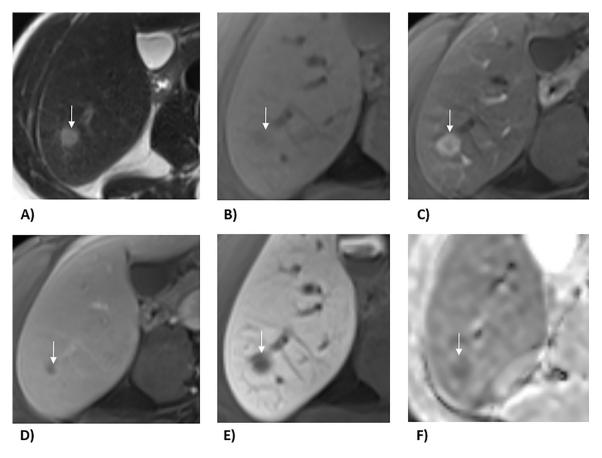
MRI of the liver with one liver lesion in segment VI. The lesion is slightly hyperintense on T2-weighted images (A). On T1-weighted images, the lesion is hypointense before contrast administration (B) and shows an avid rim-like enhancement in the arterial phase (C) with central hypointensity in the venous phase (D) and no gadoxetic acid uptake in the hepatobiliary phase (E). Diffusion-weighted imaging shows diffusion restriction (F).
